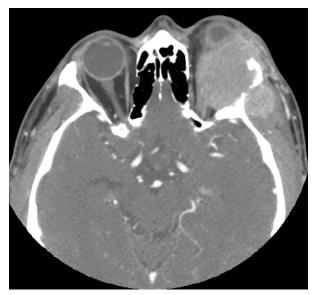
Axial image of orbital CT with contrast reveals a large left orbital mass, extending in the temporal fossa and causing bone remodeling.
